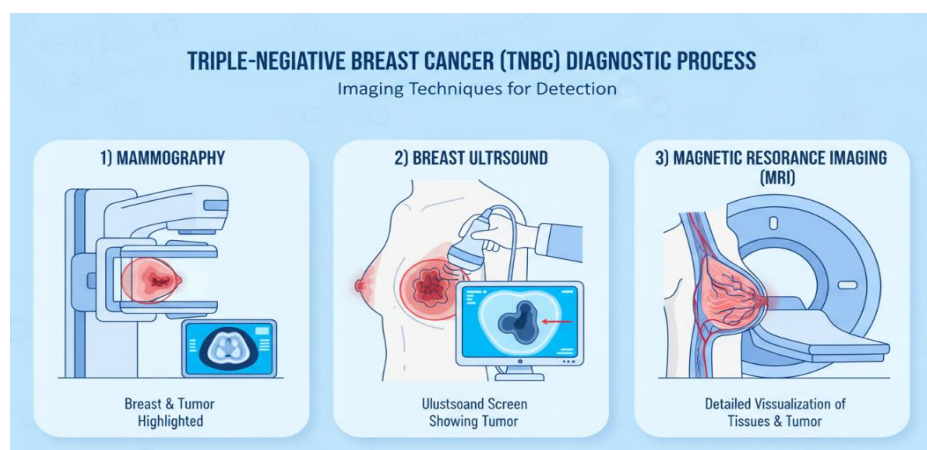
The diagnostic process for Triple-Negative Breast Cancer (TNBC) using mammography, breast ultrasound, and magnetic resonance imaging (MRI).
